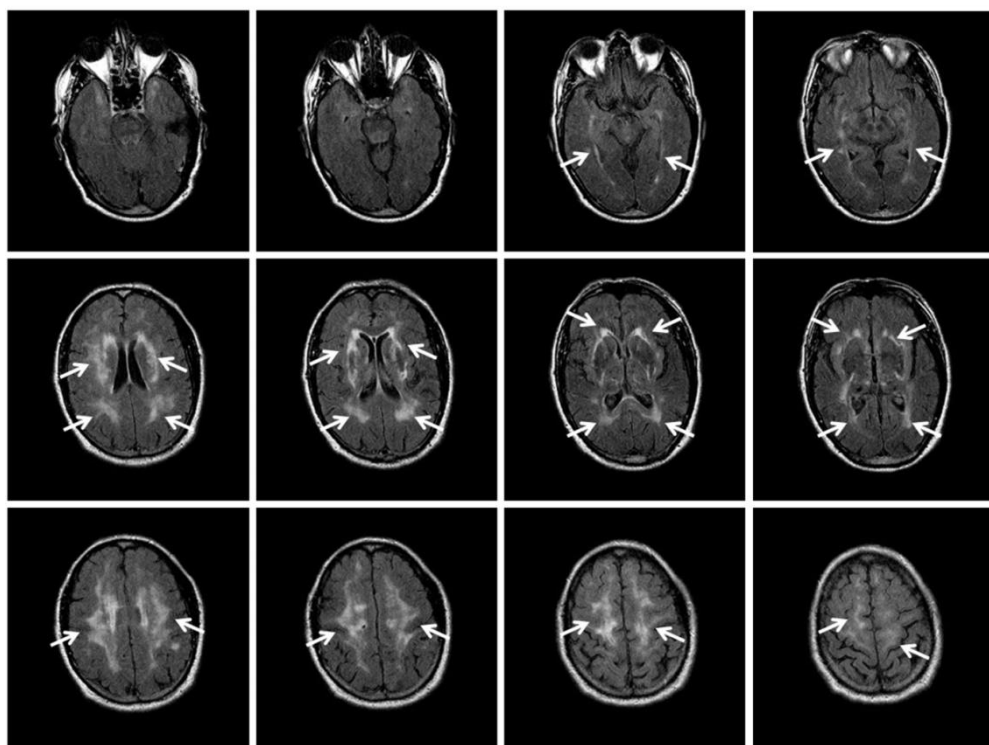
FLAIR-weighted axial MRI images from the brain of a patient diagnosed with CADASIL. White arrows indicate regions with white matter alterations. Images kindly provided by the Neurology Department of the Hospital La Princesa.
